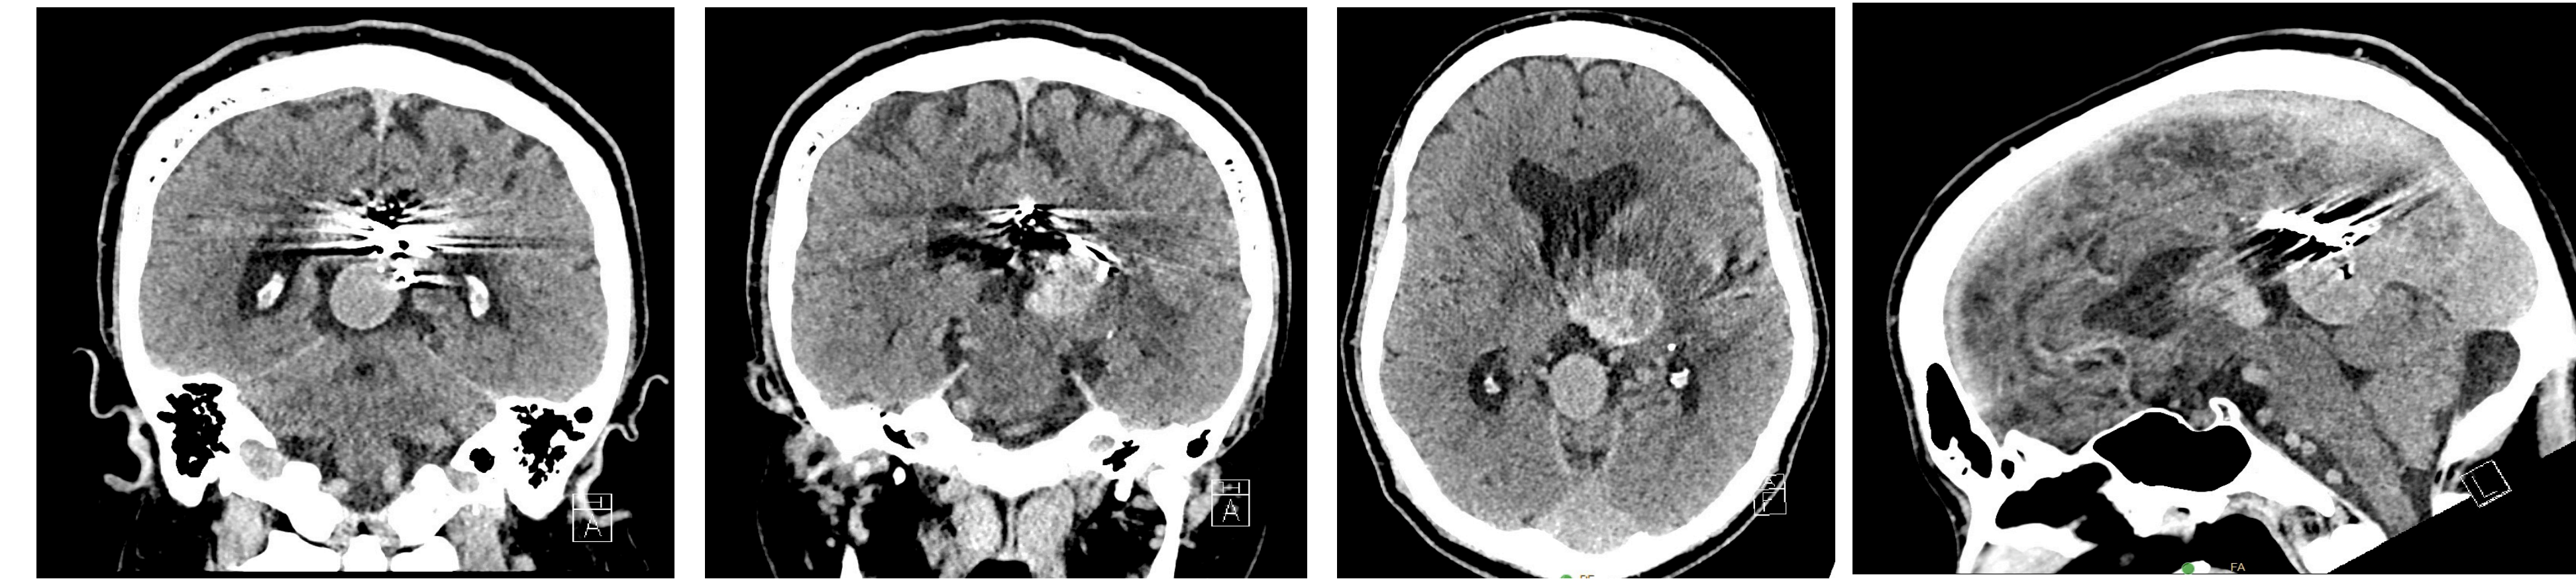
Non-contrast computed tomography shows the dilated median prosencephalic vein, left thalamic hemorrhage with edema and mass effect on the 3rd ventricle, and streak artifact from prior embolization material.
